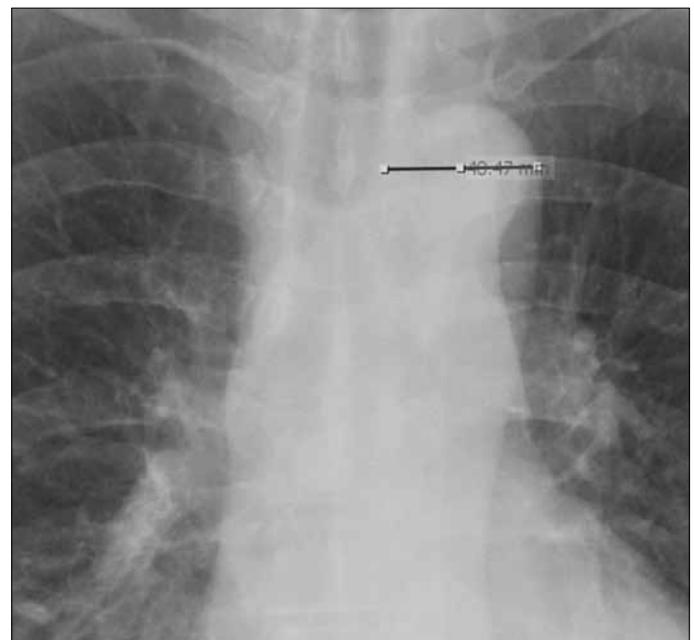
Chest X-Ray view of aortic knob width assessment
